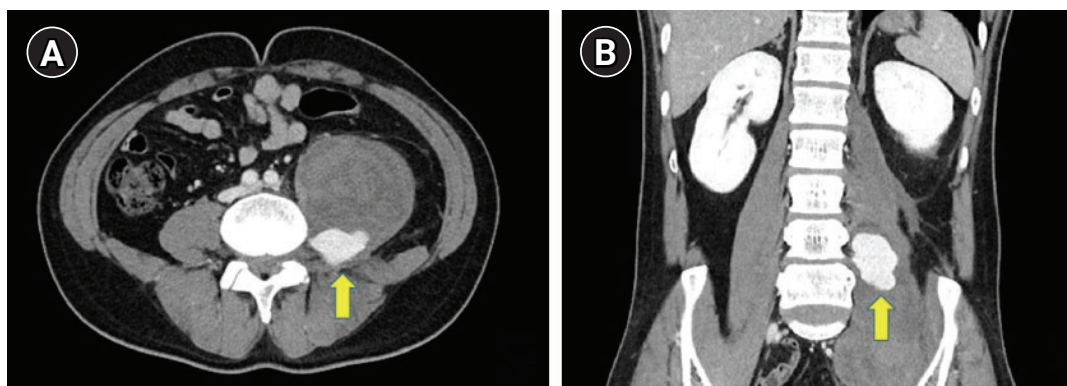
Abdomen and pelvic CT scan with contrast enhanced. Axial (A) and Coronal view (B). A huge hematoma in left psoas muscle with a large pseudoaneurysm at posterior aspect of the hematoma (arrows).
